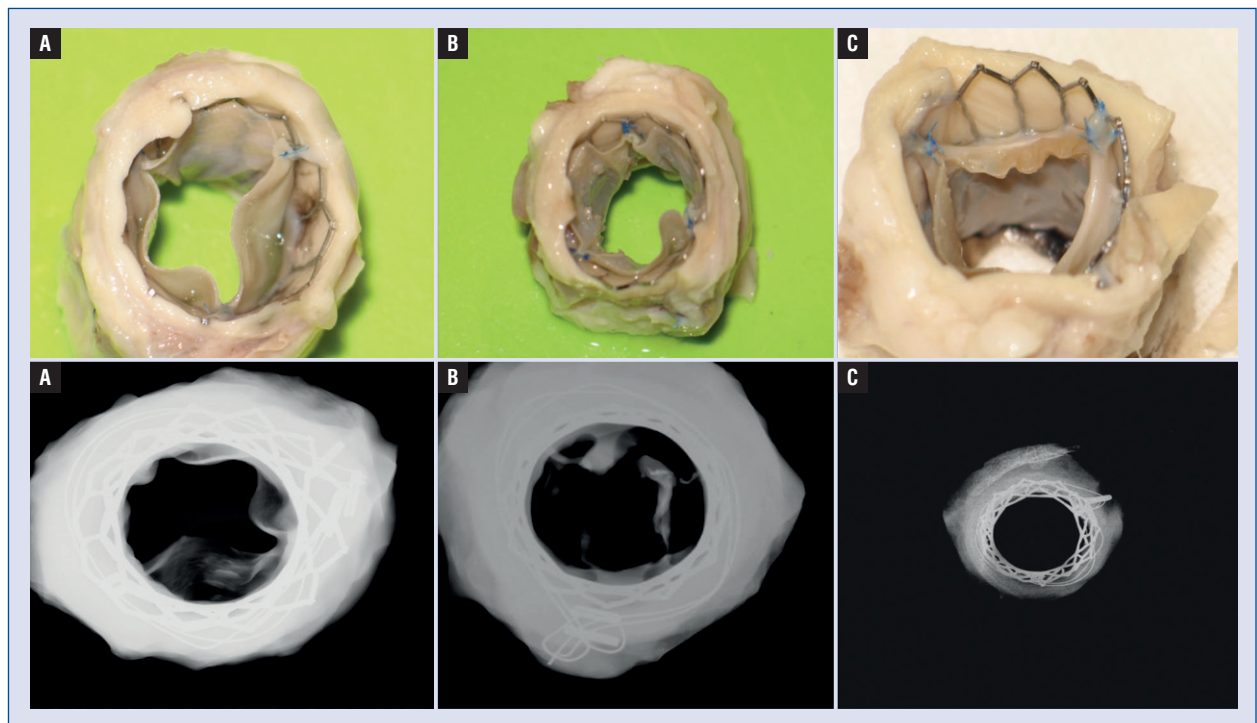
A–C. The representative images of explanted prostheses with radiograph and macroscopic inspection.
